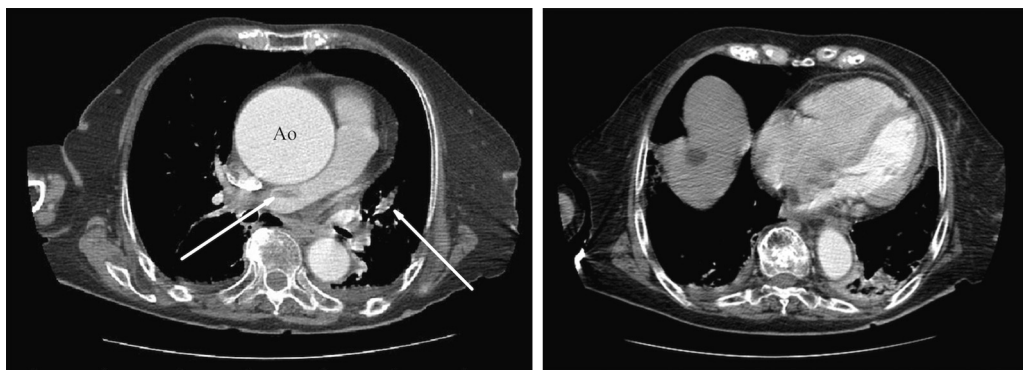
Contrast-enhanced computed tomography of the chest showing a bilateral pulmonary embolism with a large embolus in the right pulmonary artery (white arrows) and a dilated right ventricle, associated with a 70 mm aneurysm of the ascending thoracic aorta (Ao).
